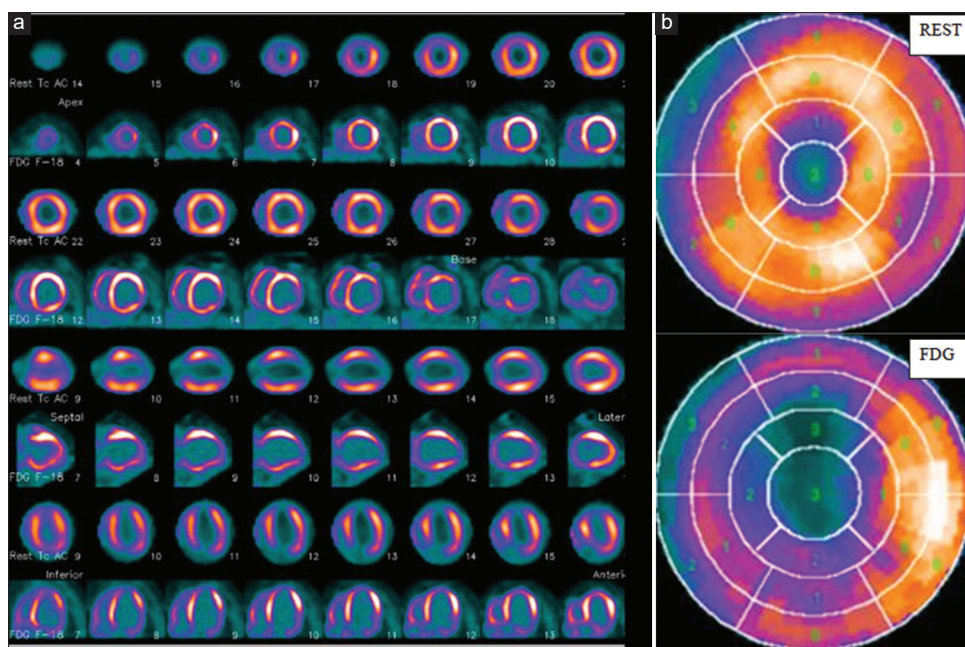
(a) Fluorine 18-fluorodeoxyglucose positron emission tomography/computed tomography and Tc-99m sesta-methoxyisobutylisonitrile myocardial viability study sectional images. (b) 17 segmental analysis showing hibernating viable myocardial segments in part of apical and mid anterior, part of anteroseptum and small part of inferolateral segments of left ventricular myocardium-4 segments. Apex and the remaining adjoining segments show scarred myocardium
